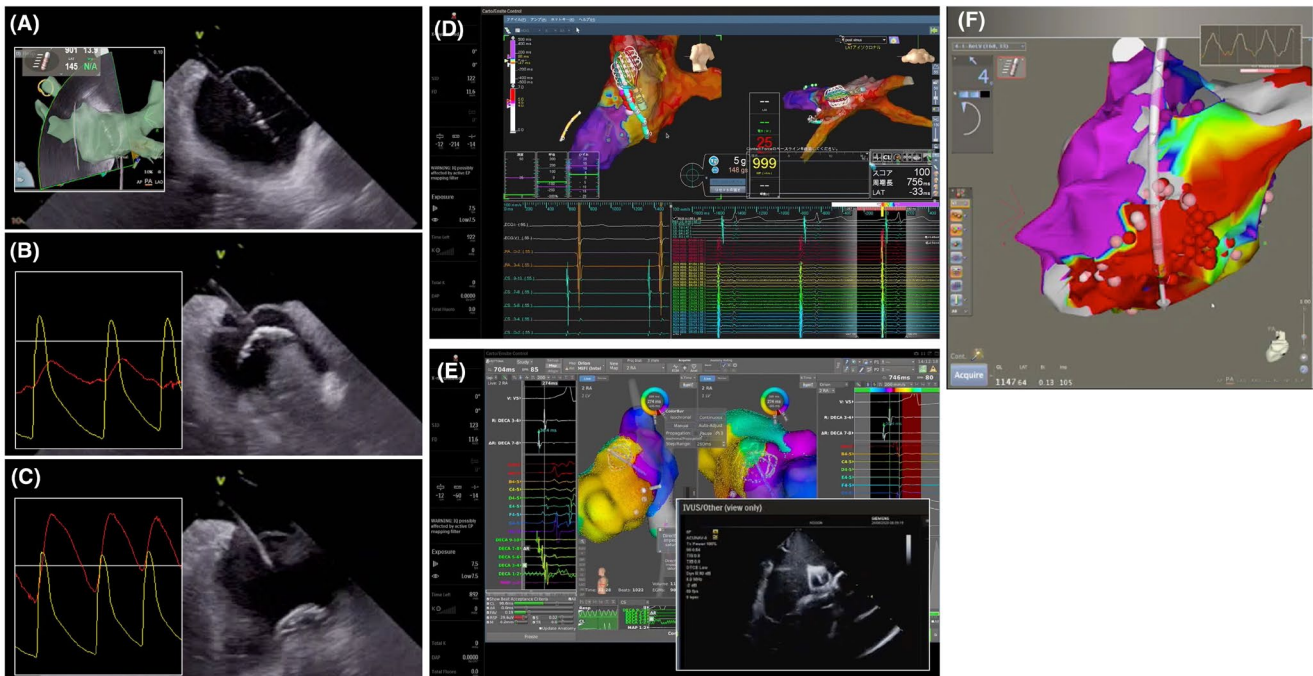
Zero-fluoroscopy ablation. (A) The 10.5 Fr (28 mm) cryoballoon and the Achieve™ mapping catheter (Medtronic) were placed through a 15 Fr steerable sheath into the LA. The Achieve™ mapping catheter was advanced into the pulmonary vein. (B) The pressure from the tip of the cryoballoon catheter was recorded. A and V waves were recorded. The cryoballoon was inflated. (C) The cryoballoon was moved to the antrum of the vein. When occlusion was achieved, there was the loss of the A wave and an increase in the amplitude and morphology of the V wave. (D) Post mapping of atrioventricular reentrant tachycardia (AVRT) ablation using the EnSite Precision™ Mapping System (Abbott, Chicago, IL, USA). The accessory pathway could be recognized. (E) A patient with Epstein's anomaly underwent AVRT ablation using the RHYTHMIA HDx™ System (Boston Scientific, Marlborough, MA, USA). The intracardiac echocardiography image showed the mapping catheter. (F) Ventricular tachycardia case. An ablation catheter was advanced retrograde to the left ventricle, and a voltage map was created under pacing rhythm. Core isolation was performed around the low voltage zone
